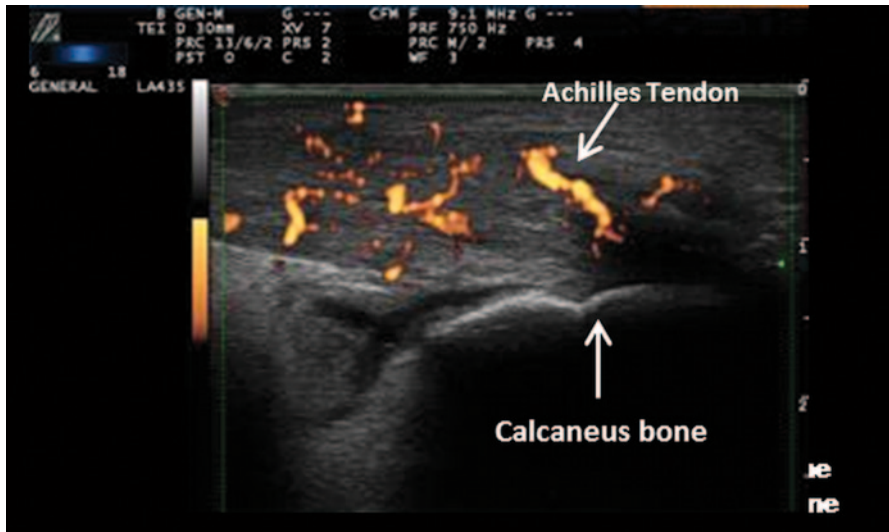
Sonographic B-mode image of Achilles tendinitis showing increased fusiform thickness of the tendon with enhanced vascularity
